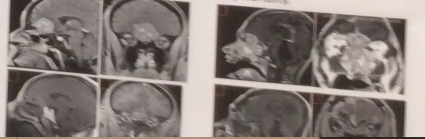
A-C: Preoperative MRI of giant OGM removed completely via open transbasal approach. D-F: Postoperative MRI showing ETR.
